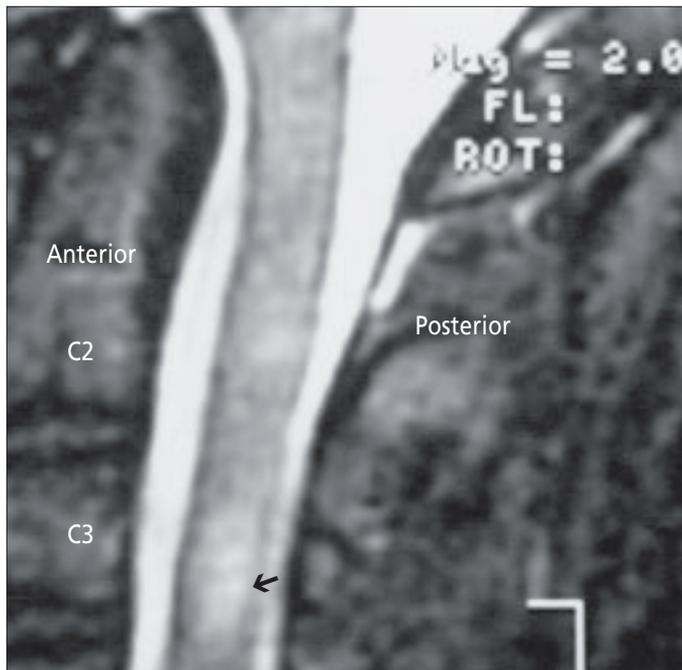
Sagittal fast spin-echo inversion recovery MR image of the cervical spine shows an area of abnormal signal intensity (arrow) in the cervical cord.
